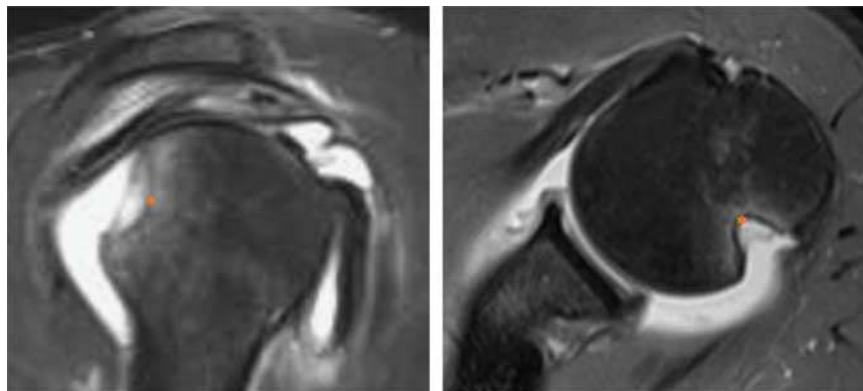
Magnetic resonance imaging showing moderate to large Hill-Sachs defect (*). full color online
